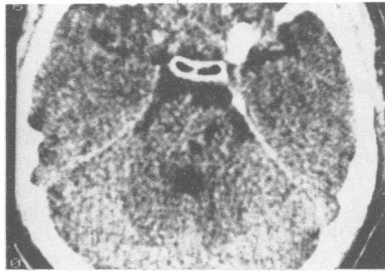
Fig High resolution CT brain scan without contrast. Axial view.
